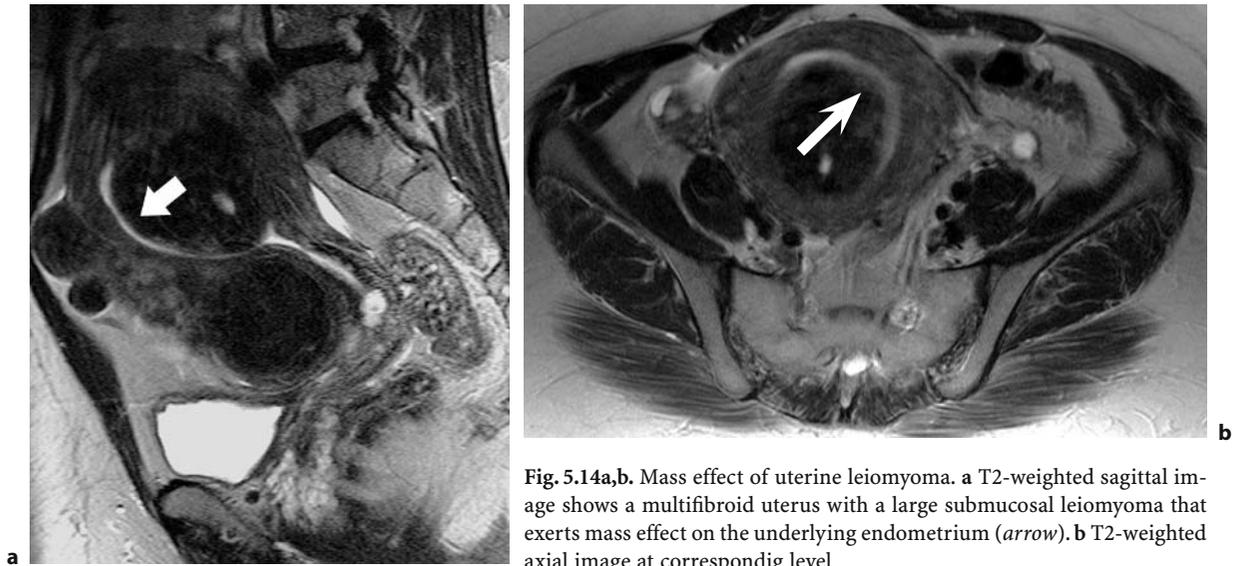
Mass effect of uterine leiomyoma. a T2-weighted sagittal image shows a multifibroid uterus with a large submucosal leiomyoma that exerts mass effect on the underlying endometrium (*arrow*). b T2-weighted axial image at correspondig level
